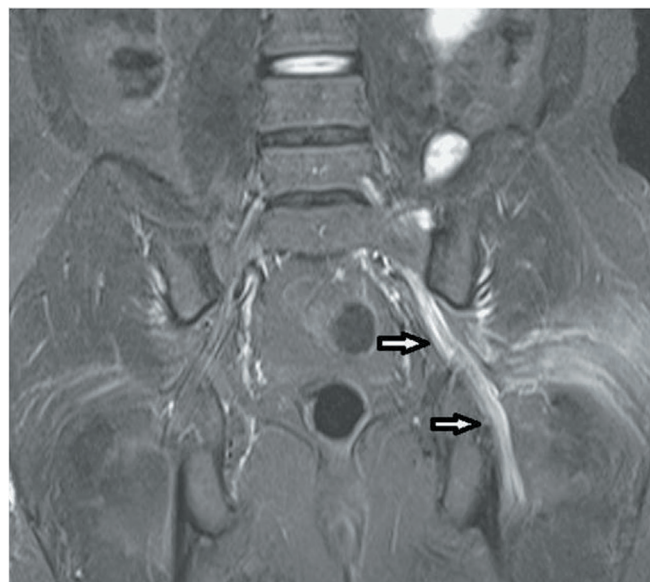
Coronal T2W fat saturated abdominal MR image shows a thickening at the left sciatic nerve (arrows).
